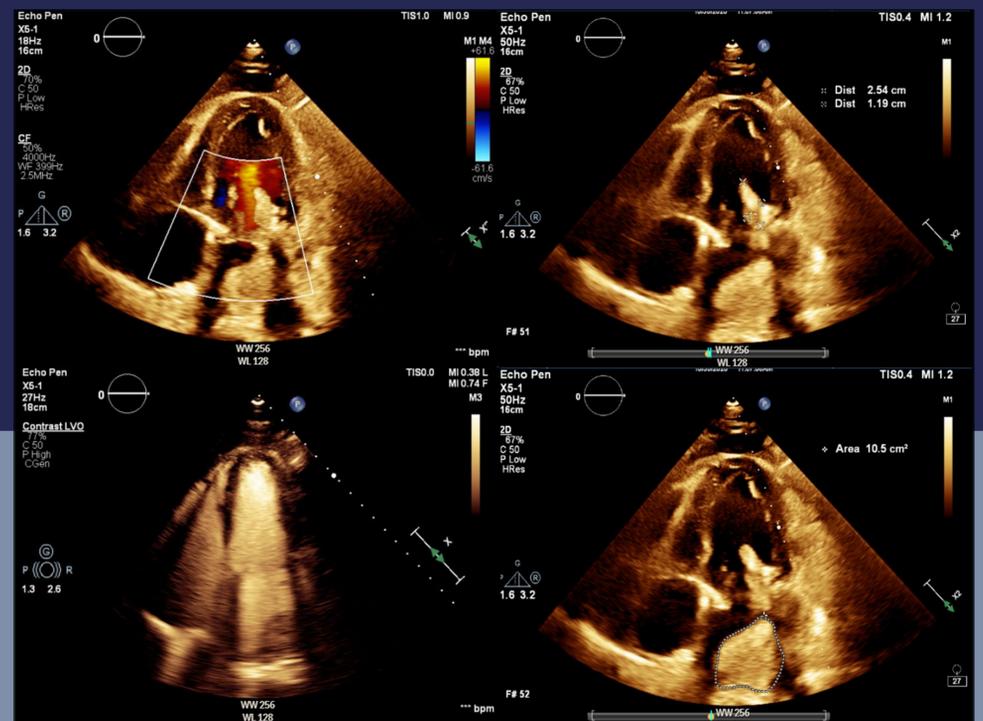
Transthoracic echocardiography (apical 4 chamber) showing large, left atrial thrombus (10.5 cm³) and moderate size bioprosthetic MV thrombus (ABOVE).
